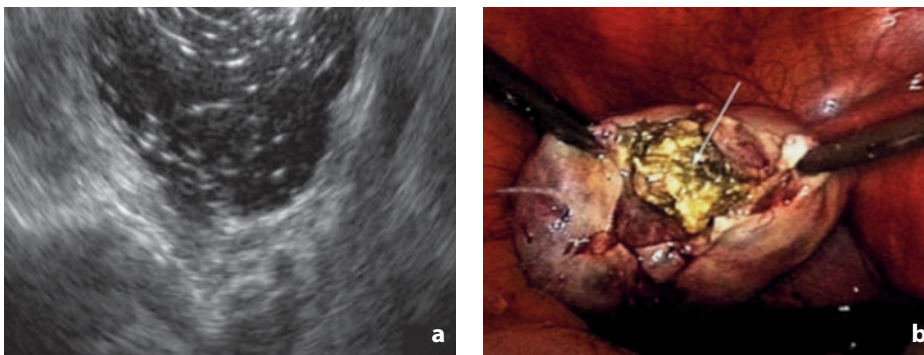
Mature cystic teratoma. Sonogram (a) and intraoperative image (b)
